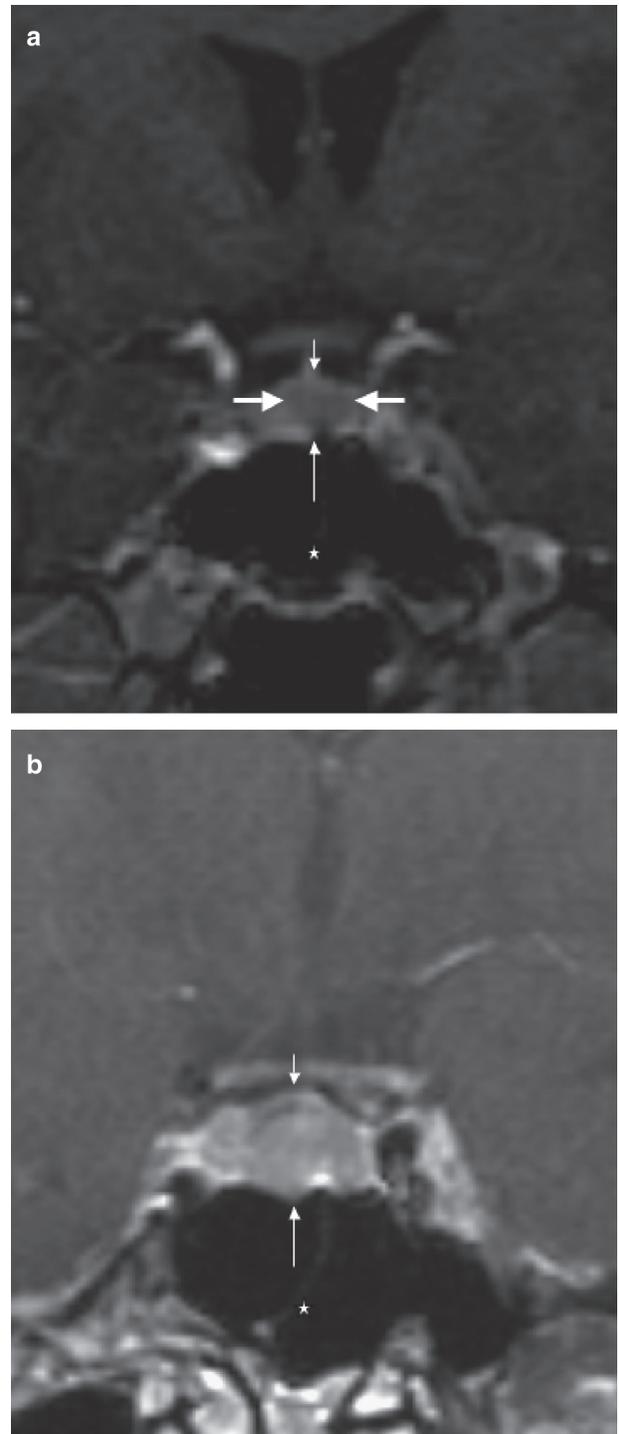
Coronal contrast enhanced T1 weighted MR image at the initial scan (a), showing a circumscribed hypointense intrapituitary lesion (thick arrows). Three-month follow-up showed only slight inhomogeneities, demonstrated on a coronal contrast enhanced T1 weighted image (b). The long arrow points at the superiorly convex margin of the adenohypophysis, the short arrow at the sellar floor. The asterisk marks the air filled sphenoid sinus.
